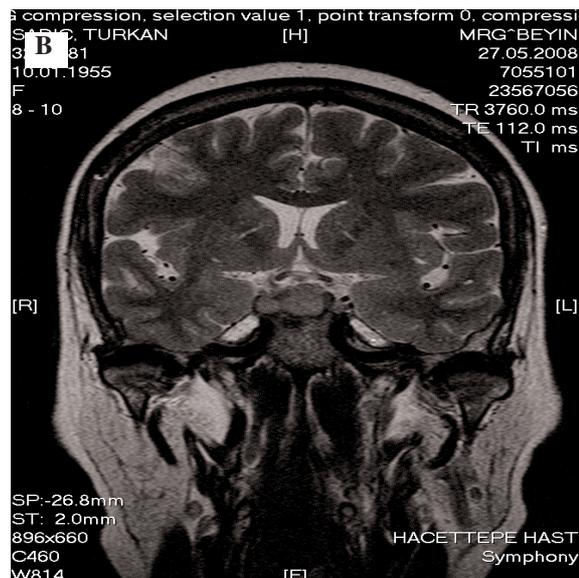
Coronal section of MRI showing pituitary mass
